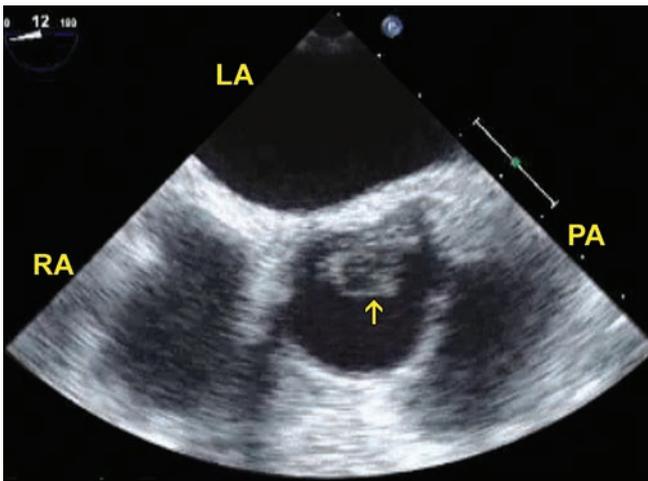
Transesophageal short axis of the ascending aorta showing a mass (arrow) partially occluding the left coronary artery.
